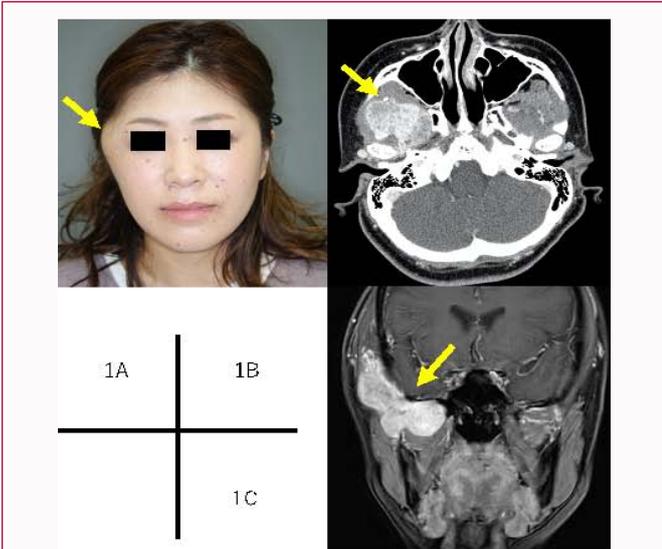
a) An elastic hard mass is observed on the right side of the temporal region; b) Contrast-enhanced computed tomography image (Axial); c) Post-contrast Magnetic Resonance Imaging (MRI) T1-weighted fat suppression image (Coronal). A well-defined tumor with a contrast effect is located from the temporal fossa to the pterygopalatine fossa. No obvious bone infiltration is observed in the cheekbone, mandible, or sphenoid bone. The surrounding masticatory muscles are thinned, but no obvious infiltration is observed.
